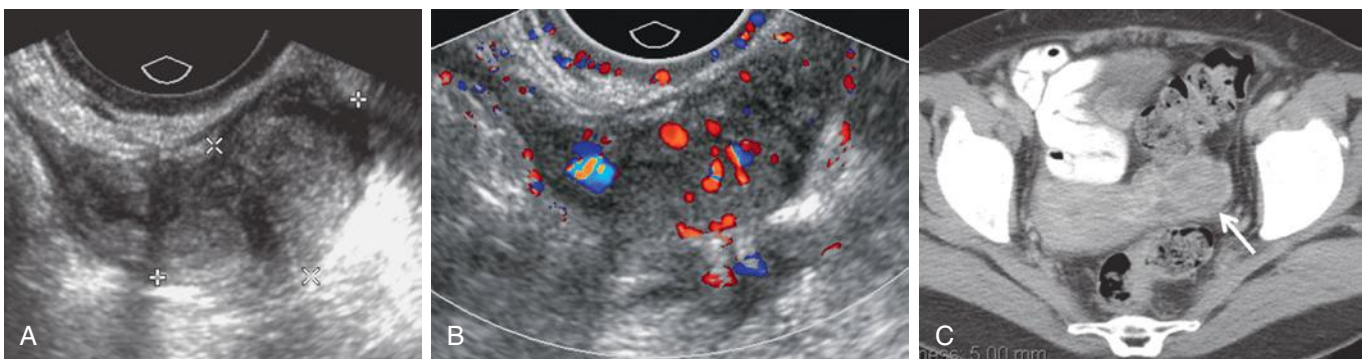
Enlarging solid ovarian mass found on serial sonograms in patient with history of endometriosis. A, Transvaginal sonography demonstrates a solid mass (calipers) in the left ovary. B, Increased vascularity is demonstrated in the mass with color Doppler sonography, confirming solid nature. C, Contrast-enhanced computed tomography scan demonstrates the primarily solid, heterogeneously enhancing left ovarian mass (arrow). Patient underwent surgery and was found to have endometrioid adenocarcinoma with foci of squamous and clear cell differentiation involving the left ovary and fallopian tube arising in a background of endometriosis.
